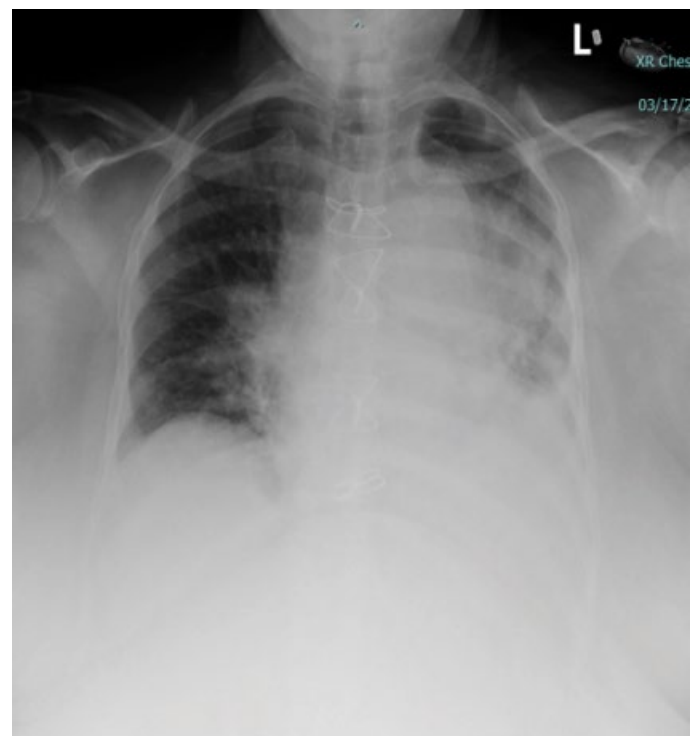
Chest X-ray showed bilateral lung opacities, left greater than right.
